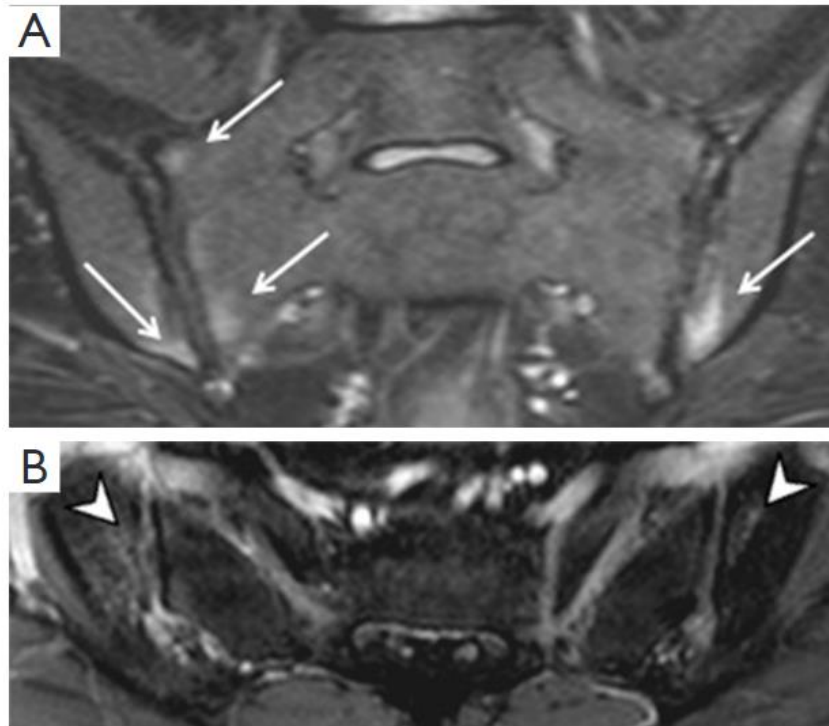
Sacroiliitis on MRI. (A) Bone marrow oedema (arrows) on T2W FS oblique coronal images and (B) corresponding enhancement (arrowheads) on T1W FS post-contrast axial images. This degree of bone marrow oedema is sufficient to diagnose sacroiliitis.
